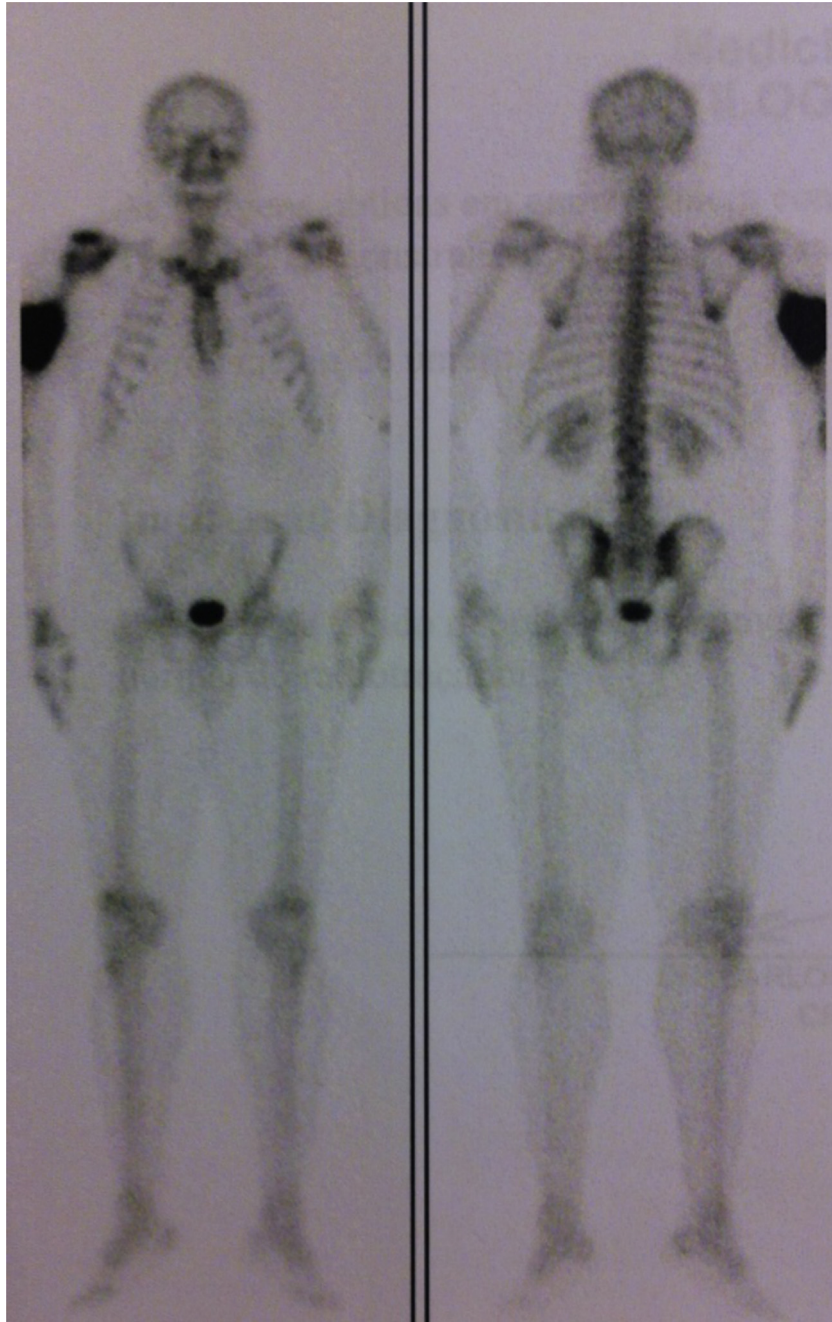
Bone scintigraphy.
